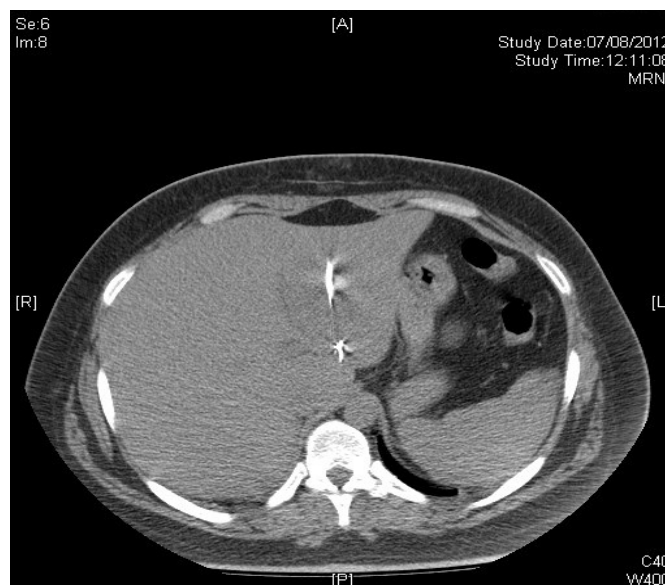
Drainage under CT control
